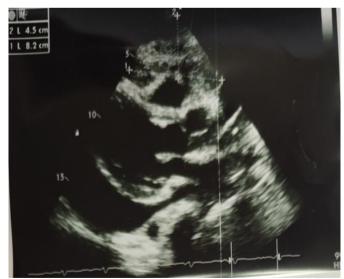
Transesophageal echocardiography showed an echogenic mass measuring 4×9 cm, originating from the free wall of the right ventricle. It exerted pressure on the right ventricular outflow tract and pulmonary artery within the pericardial space.
